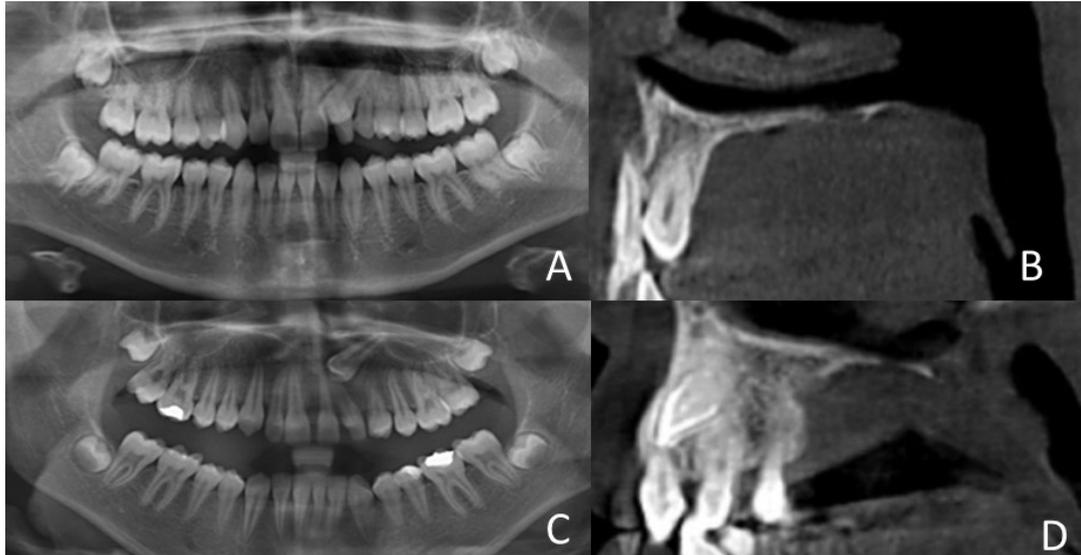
Contact relationship of IPMC with adjacent PLI. (A&B) Contact relationship in the cervical third of the root on DPR image and CBCT image in the sagittal plane. (C&D) Contact relationship in the apical third of the root on DPR image and CBCT image in the sagittal plane.
